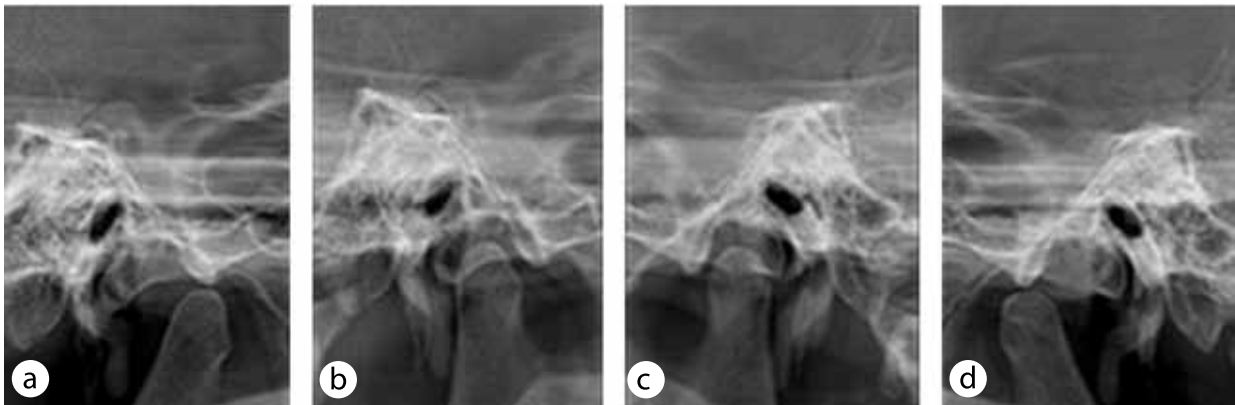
Temporomandibular joint radiographs in the lateral projection: a — position open to the right, b — position closed to the right, c — position closed to the left, d — position open to the left
